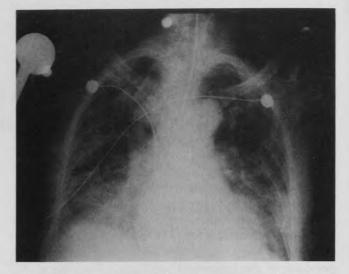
Roentgenogram of chest showing woolly infiltrates in both lung fields with normal cardiac silhouette.
